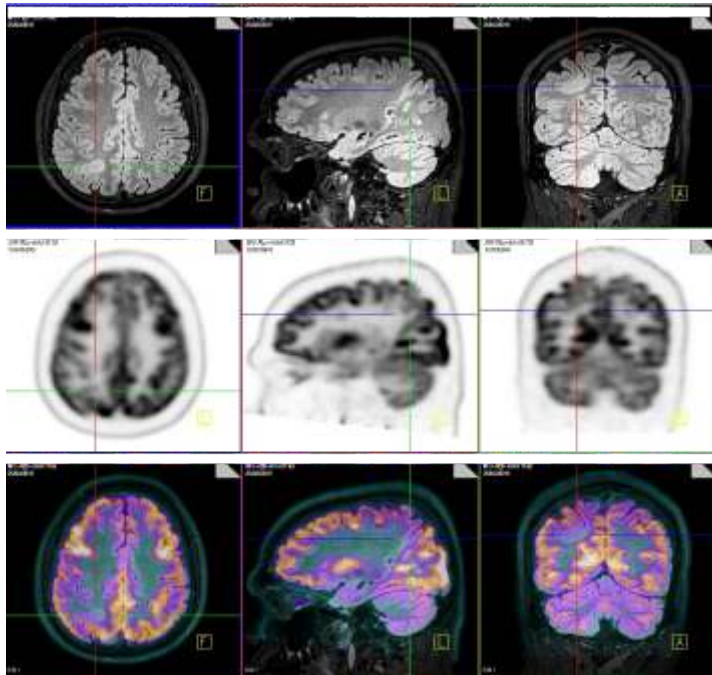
Top row shows MRI findings of right parietal balloon cell dysplasia
